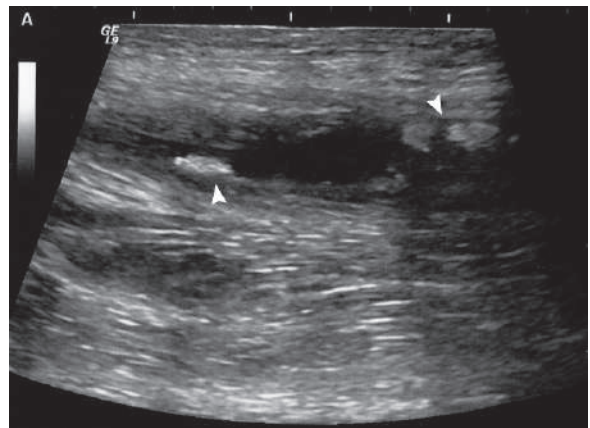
Sagittal ultrasound image of the superficial femoral artery in a diabetic shows multiple dense calcifications of the arterial wall (*arrowheads*)
